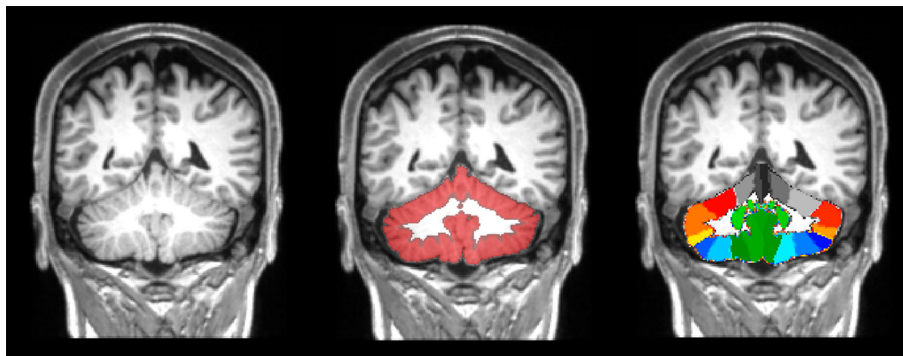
Lesion-filled T1-weighted coronal reconstruction of a 57-year-old male patient with MS. In the middle, the isolated cerebellar grey matter in red obtained by SUIT is superimposed to the T1-weighted image. On the right, the SUIT cerebellar atlas aligned in the native subject space.
